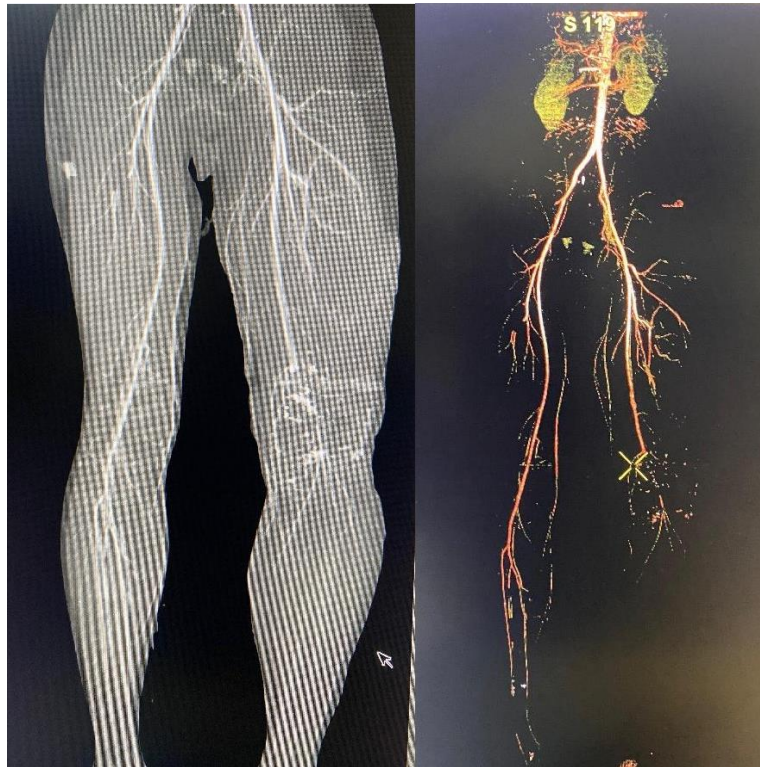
MRI of the patient when referred to Gatot Subroto Army Hospital
